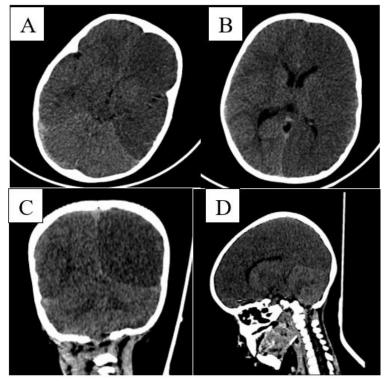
Head CT scan in axial (A, B), coronal (C) and sagittal (D) sections revealing diffuse hemispheric cerebral edema marked in the left side, with increased attenuation of the thalami and cerebellum
